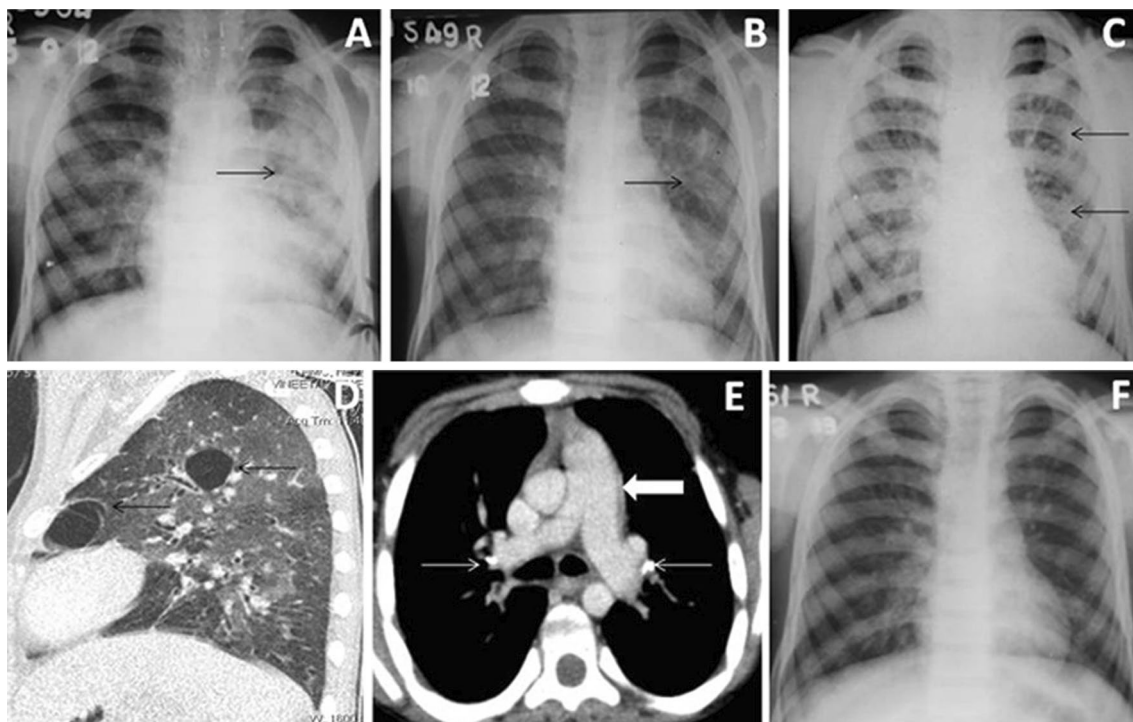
Bacterial Infection. Frontal chest radiograph (CXR) in a 12-year-old HIV-positive male reveals diffuse consolidation (arrow in A) involving left lung field. After start of antibiotics, the consolidation showed gradual resolution (arrow in B), with appearance of two oval cystic lucencies (arrows in C) in left upper & mid zones suggesting pneumatocele formation. CT chest (sagittal plane in lung window) confirmed presence of pneumatoceles in left upper lobe (arrows in D). Axial CT in soft tissue window (E) showed enlarged pulmonary artery (thick arrow) suggestive of pulmonary hypertension, and few calcified mediastinal/hilar lymph nodes (thin arrows). Patient's CD4 count was 354 cells/cu.mm. Sputum isolated pneumococcus. Patient showed complete clinical and radiological improvement after a course of antibiotic with non-visualization of pneumatoceles on follow-up CXR (F)
